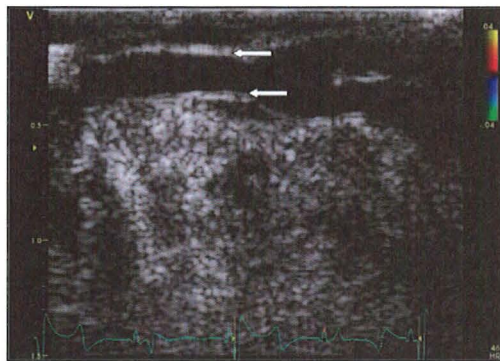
Ultrasound scan of the left internal mammary artery-left anterior descending artery anastomosis in longitudinal view by B-mode. The anterior and posterior intimal echo patterns are shown by arrows. The intimal echo pattern indicates that the ultrasound beam is perpendicular to the left anterior descending artery intima. The left internal mammary artery is seen top right and the flow direction is to the left of the picture.
